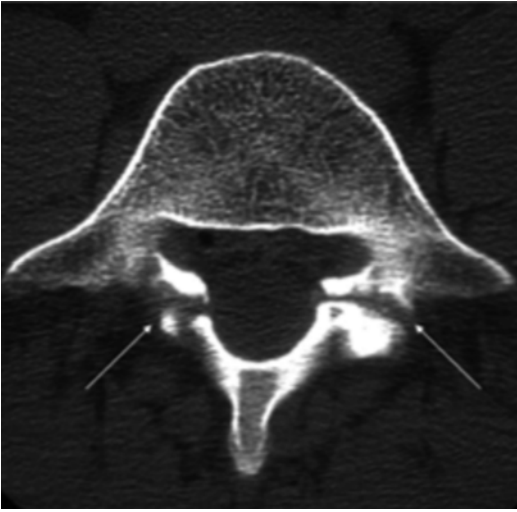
Axial CT scan demonstrating bilateral fractures of the pars interarticularis (*arrows*)
